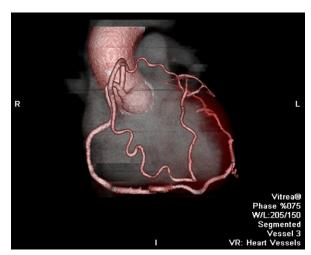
Three-dimensional computed tomographic angiographic rendering (anteroposterior view) shows an entire coronary system arising from a single coronary ostium in the right coronary sinus of Valsalva.
